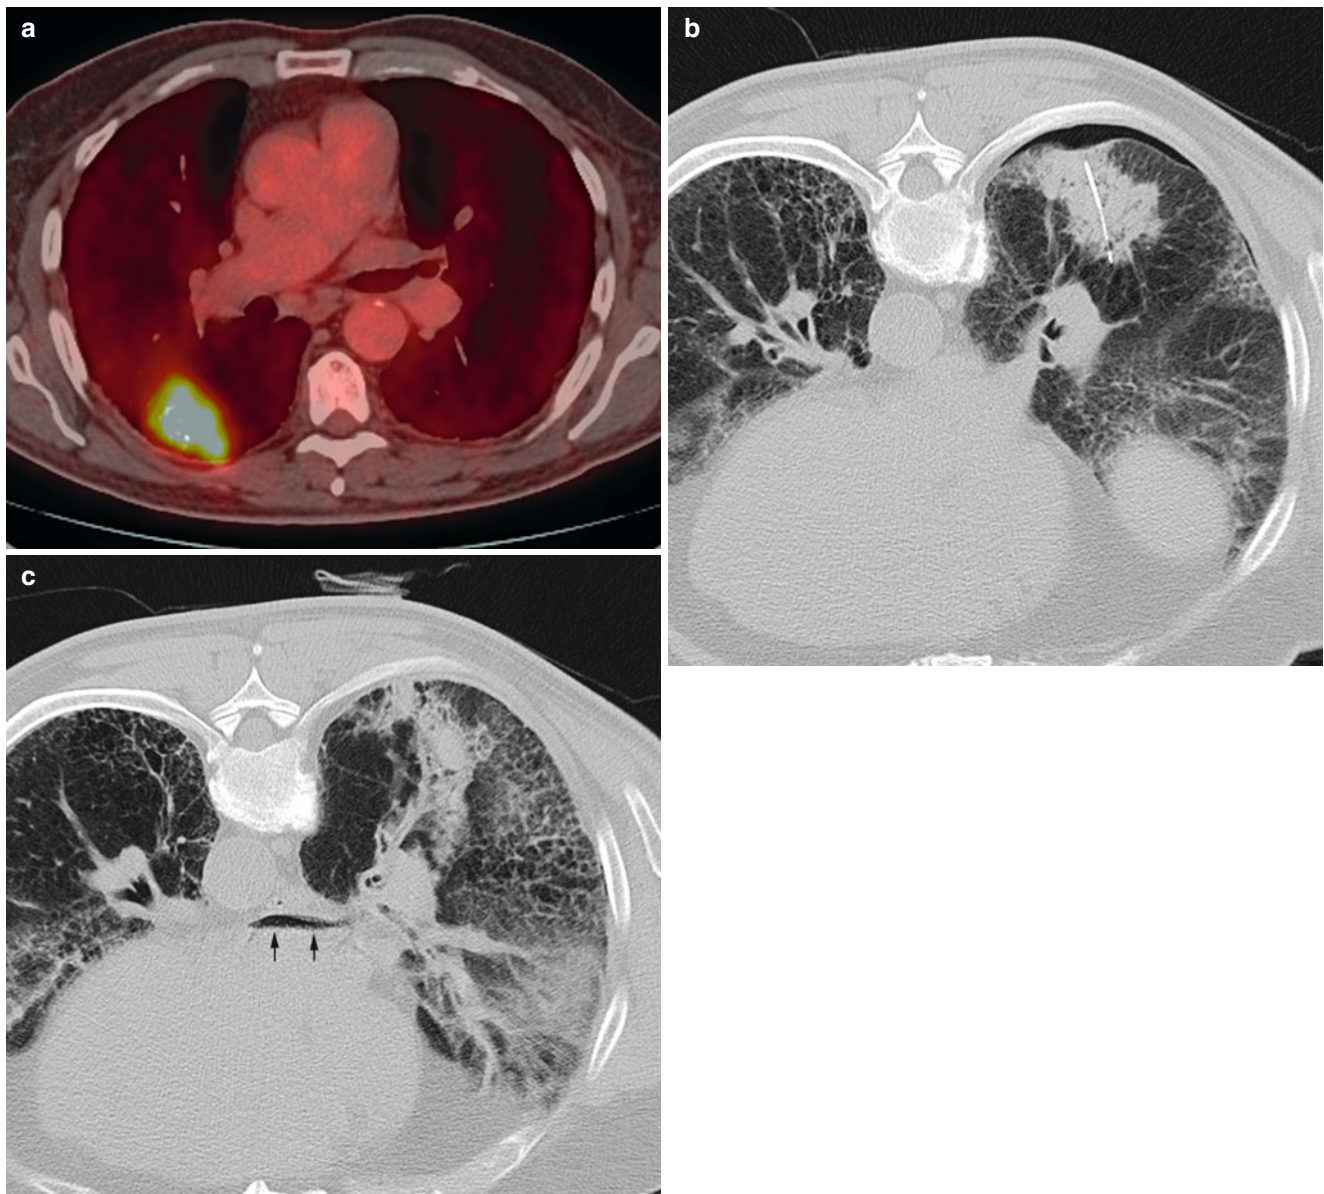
A 75-year-old man with severe emphysema was found to have a mass in the right lower lobe. Axial PET/CT image of the mass (a) shows high metabolic activity. CT image of the patient in prone position shows the needle tip within the mass (b) and small pneumothorax.
